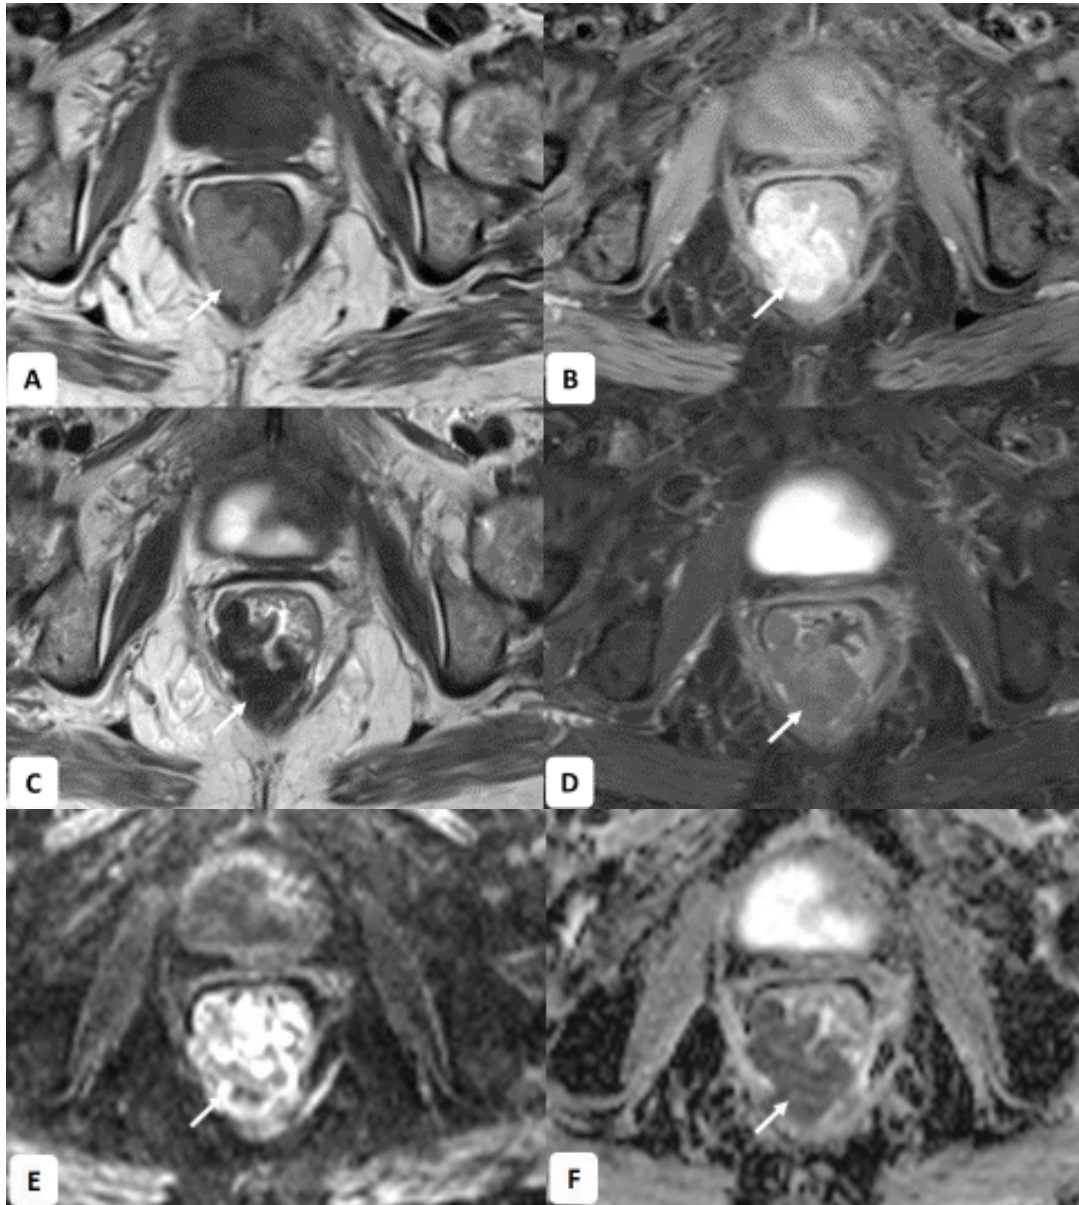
MRI of the pelvis in axial T1W (A), T1WFS (B), T2W (C), post-contrast T1W (D), DWI at 800 b-value (E) and ADC (F) sequences highlighting bulky intraluminal polypoidal mass (white arrow) obscuring the lumen. The mass demonstrates T1W/T1WFS hyperintensity, T2W hypointensity, restricted diffusion in DWI/ADC and heterogenous enhancement on post-contrast.
